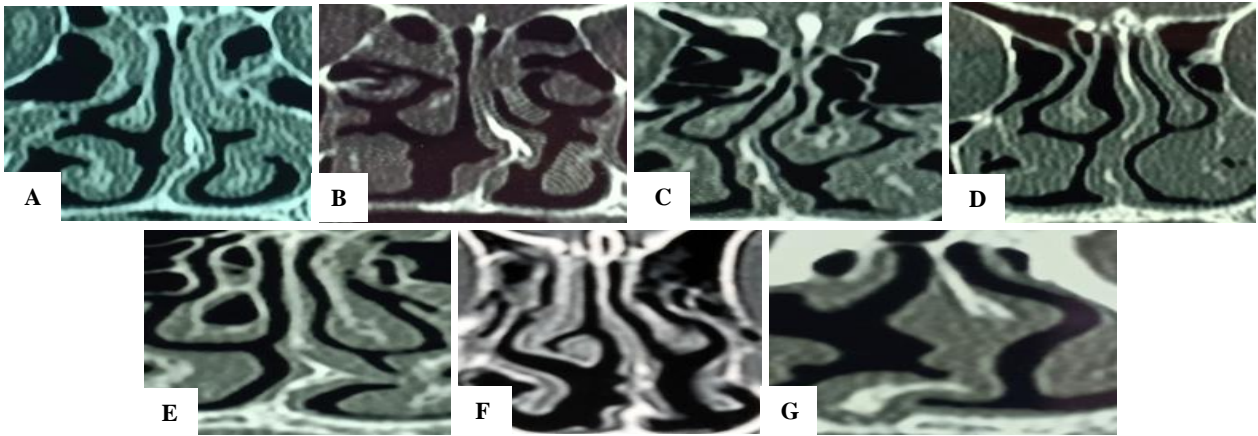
Computed tomography of paranasal sinuses (coronal section) indicating various types of Mladina's classification of deviated nasal septum (A) type I, (B) type II, (C) type III, (D) type IV, (E) type V, (F) type VI, (G) type VII.
